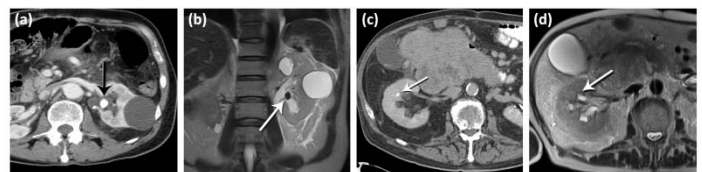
CT (a,c), and the corresponding MRI (b,d) images of two cases. (a,b) Enhanced axial CT demonstrates a large stone in the left renal pelvis (arrow), which was detected as hypointense (arrow) in the coronal HASTE MRI image against the backdrop of hyperintense urine. (c,d) Contrast-enhanced CT performed for tumor staging reveals a stone in a right renal interpolar calyx (arrow), which was not detected in the same calyx on the axial MRI HASTE image.
